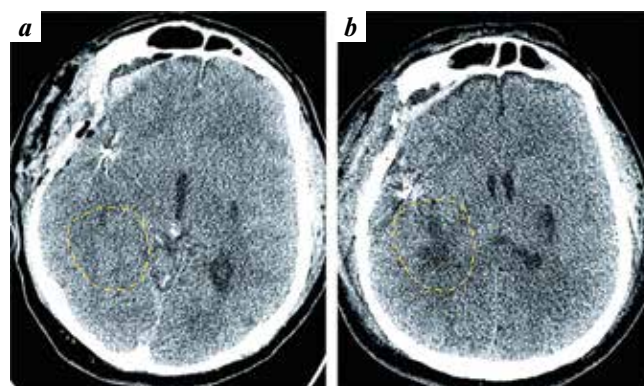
Computed tomography of the brain of patient 1: *a* – immediately after the operation of clipping the M3 segment aneurysm of the right middle cerebral artery: no data for ischemic changes were found; *b* – three days after operation: the formation of an ischemic zone (marked with a yellow dashed line) of the deep sections of the right temporal lobe outside the trepanation window is visible
